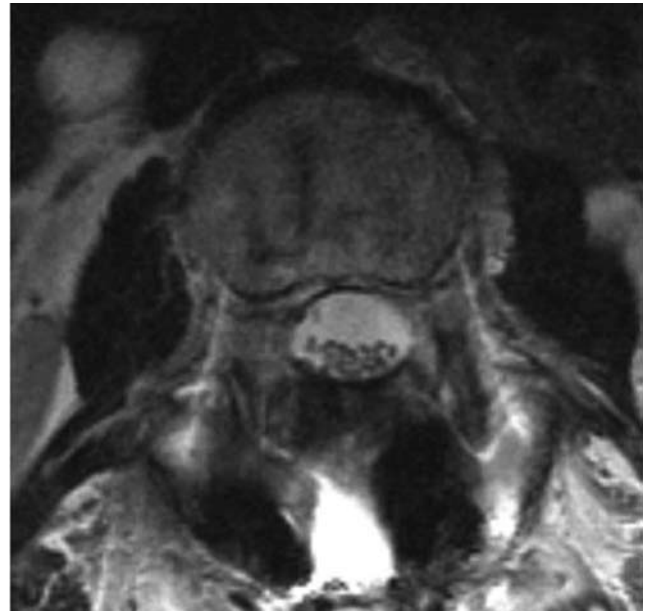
Case 1. Postoperative axial MR image revealing no arachnoid cyst and good decompression of the cauda equina.
